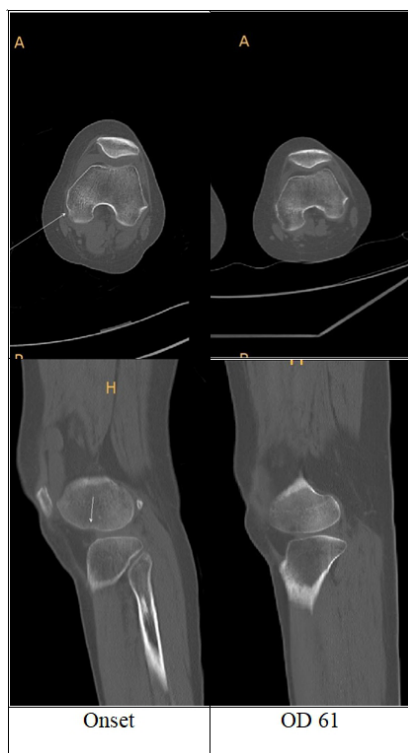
Computed tomography of the left medial femoral condyle. OD, onset day: days after the onset.
